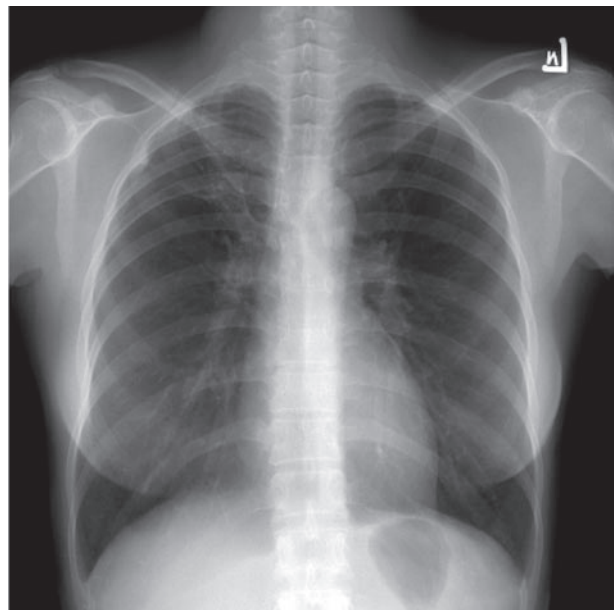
Normal chest radiograph 15 days after admission.
